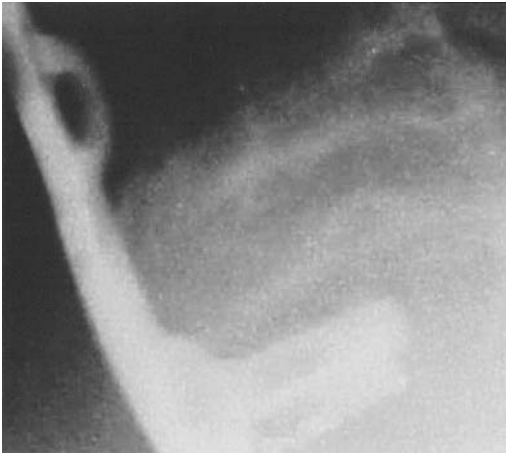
The same patient as in [Fig. 4](#), 2 years postoperatively with apparent radiographic union.
